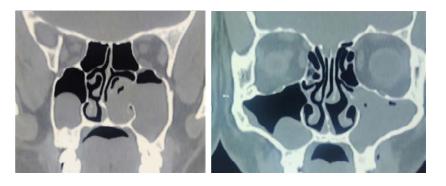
Computed Tomography (Ct)Scan Paranasal Sinuses (Coronal View) Showing Left Maxillary Sinus Filled Up with Homogenous Soft Tissue.
